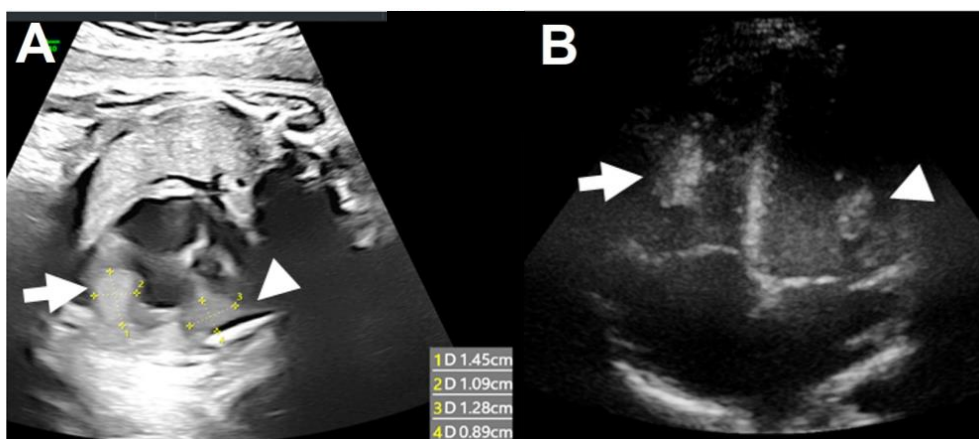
Echocardiography findings revealed multiple rhabdomyomas without significant change in size. Rhabdomyomas on the right ventricle (RV) are indicated by arrows, and rhabdomyomas on the left ventricle (LV) are indicated by arrowheads. (A) Echocardiography performed on 2 days after birth identified, 3 masses: RV, 15×10 mm; septum, 3×4 mm; and LV, 11×11 mm. (B) Echocardiography performed on 5 months of age identified, 3 masses: RV, 12×8 mm; septum, 3×4 mm; and LV, 13×8 mm.
